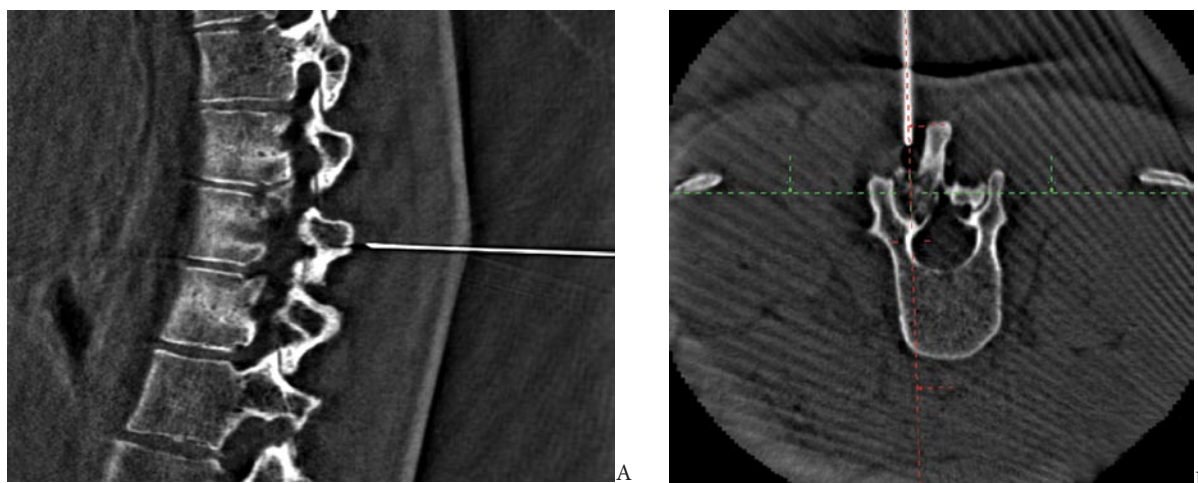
A 25-year-old female with mid-thoracic back pain and lytic lesion of the left T9 lamina thought to represent osteoid osteoma. The patient was referred for preoperative paraspinal fiducial marker placement near the lesion prior to image-guided resection by an orthopedist. Sagittal and axial reformatted images (panels A and B) of a fluoroscopic CT acquisition were used to guide placement of the introducer needle tip into the paraspinal soft tissues adjacent to the lytic lesion of the T9 lamina. Panel C is an axial reformatted image from a subsequent fluoroscopic CT acquisition showing satisfactory final positioning of 5 gold fiducial markers at the level of T9; 2 at the transverse process, 2 at the lamina, and one at the spinous process.
